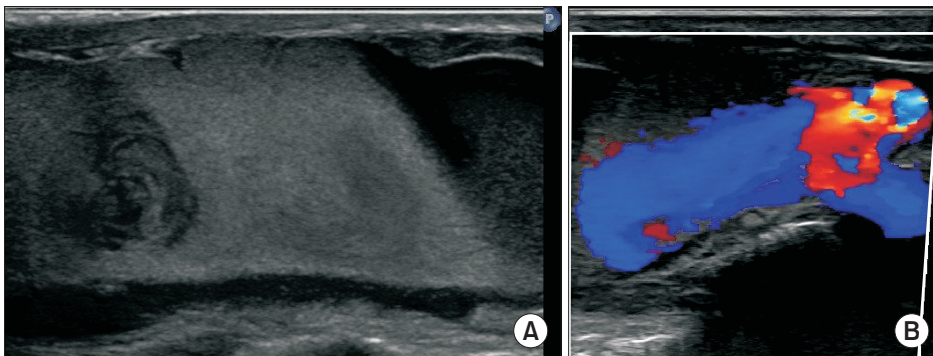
Duplex ultrasonography performed with a Philips Afiniti 30. (A) B-mode image shows an anechoic, longitudinal mass with blood elements flowing and swirling within a collection. (B) Color Doppler image shows blood spreading from the dorsalis pedis artery to the surrounding tissue with a wide neck.
